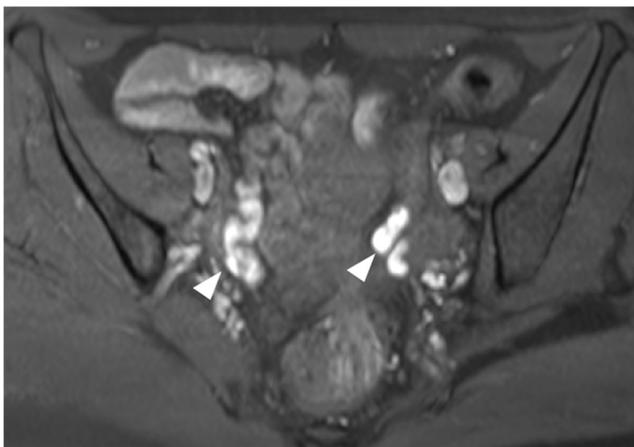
Bilateral salpinx with distal obstruction. Arrowheads show distal occlusion of right and left fallopian tubes that are gadolinium-contrast filled. Salpinges were not recognised on morphological sequences because of their non-fluid signal on T2-weighted images. They were revealed on intra-cavity injection. The MR-HSG attests to the absence of peritoneal spill
